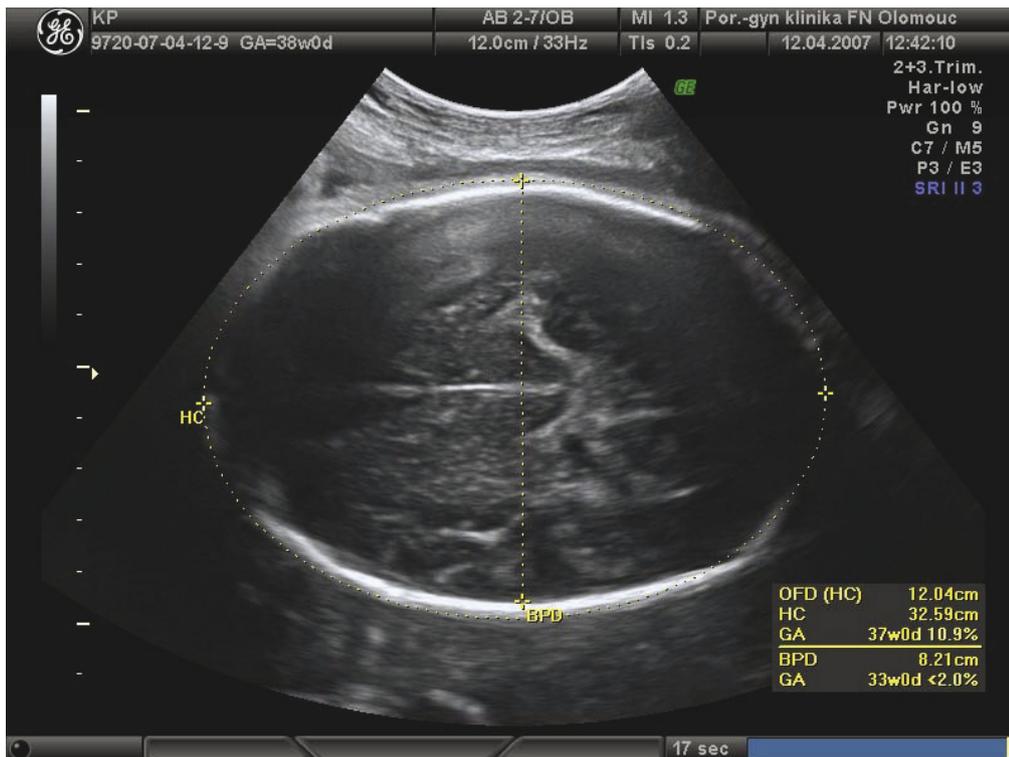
The “Breech Head” ultrasound scan at 37th week (HC – head circumference – 326 mm – 37w0d, BPD – biparietal diameter – 82 mm – 33w0d, OFD – occipitofrontal diameter – 120 mm, OFD/BPD ratio = 1,46).
